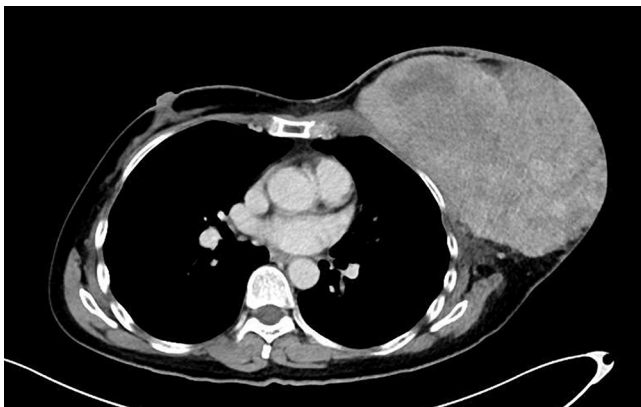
Computed Tomography of Chest demonstrating the left breast mass.
